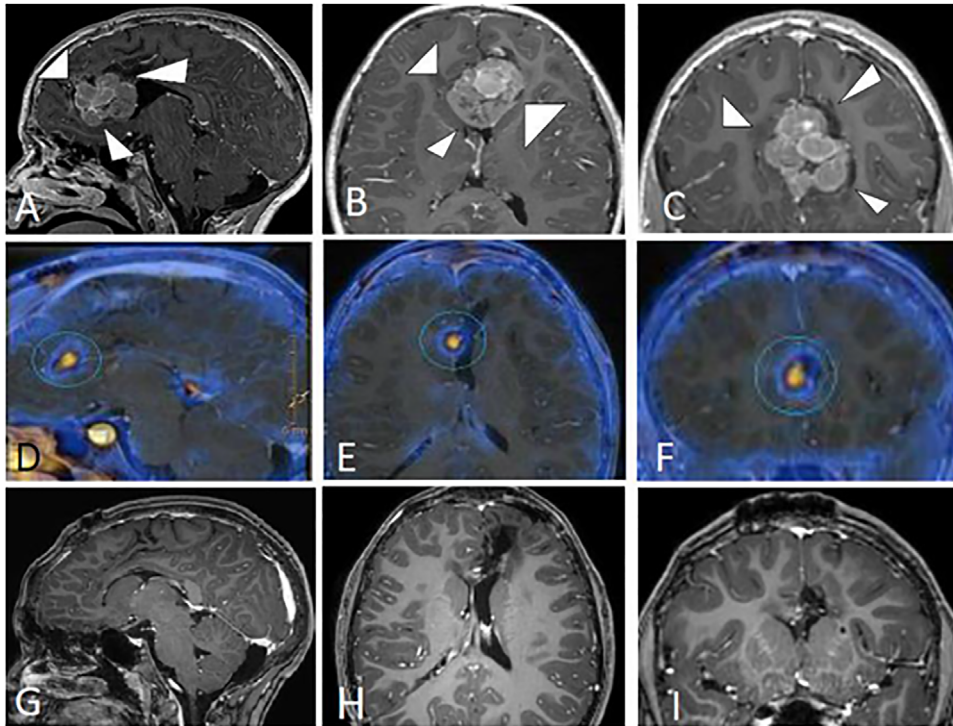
MRI of a child with frontal lobe atypical meningioma. Presurgical MRI: (A–C) sagittal, axial, and coronal 3D T1-weighted multiplanar reconstructions (MPR). Meningioma arising from the frontal lobe with signs of intraslesional hemorrhage (arrowheads); postsurgical/preprotontherapy MRI/PET: (D–F) sagittal, axial, and coronal Gallium-68 DOTATOC PET fused with 3D T1-weighted postoperative MRI; noticeable small hypercaptating nodule in the frontal tumor bed (ring). Postprotontherapy MRI 30 months after treatment: (G–I): sagittal, axial, and coronal 3D T1-weighted. No evidence of residual tumor
